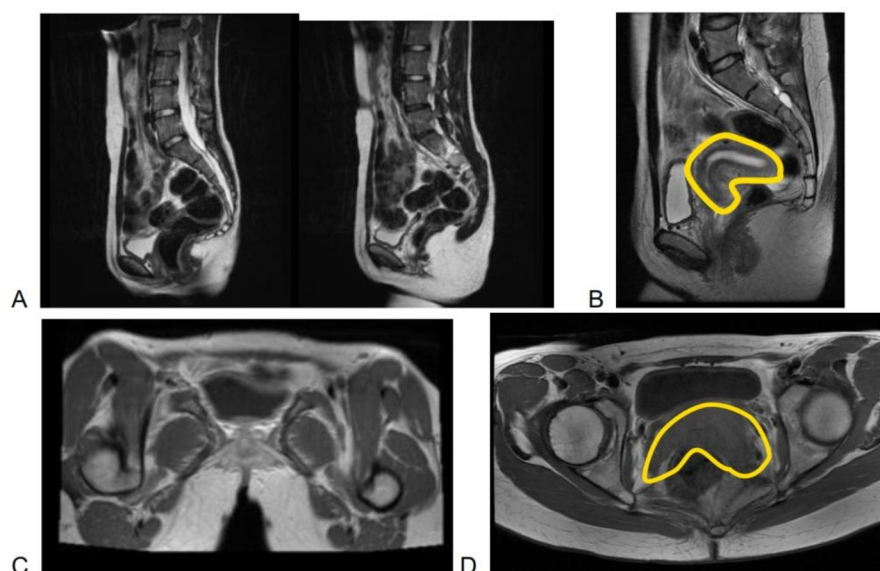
Pelvic MRI plain and contrast. A: Patient, T2-weighted sagittal view. B: Normal, T2-weighted sagittal view demonstrating the presence of a uterus. C: Patient, T1-weighted axial view. D: Normal, T1-weighted axial view demonstrating the presence of a uterus.
